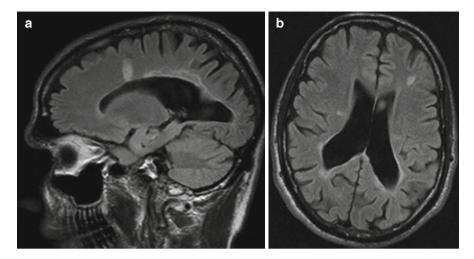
(a, b) Periventricular and juxtacortical lesions on MRI brain
